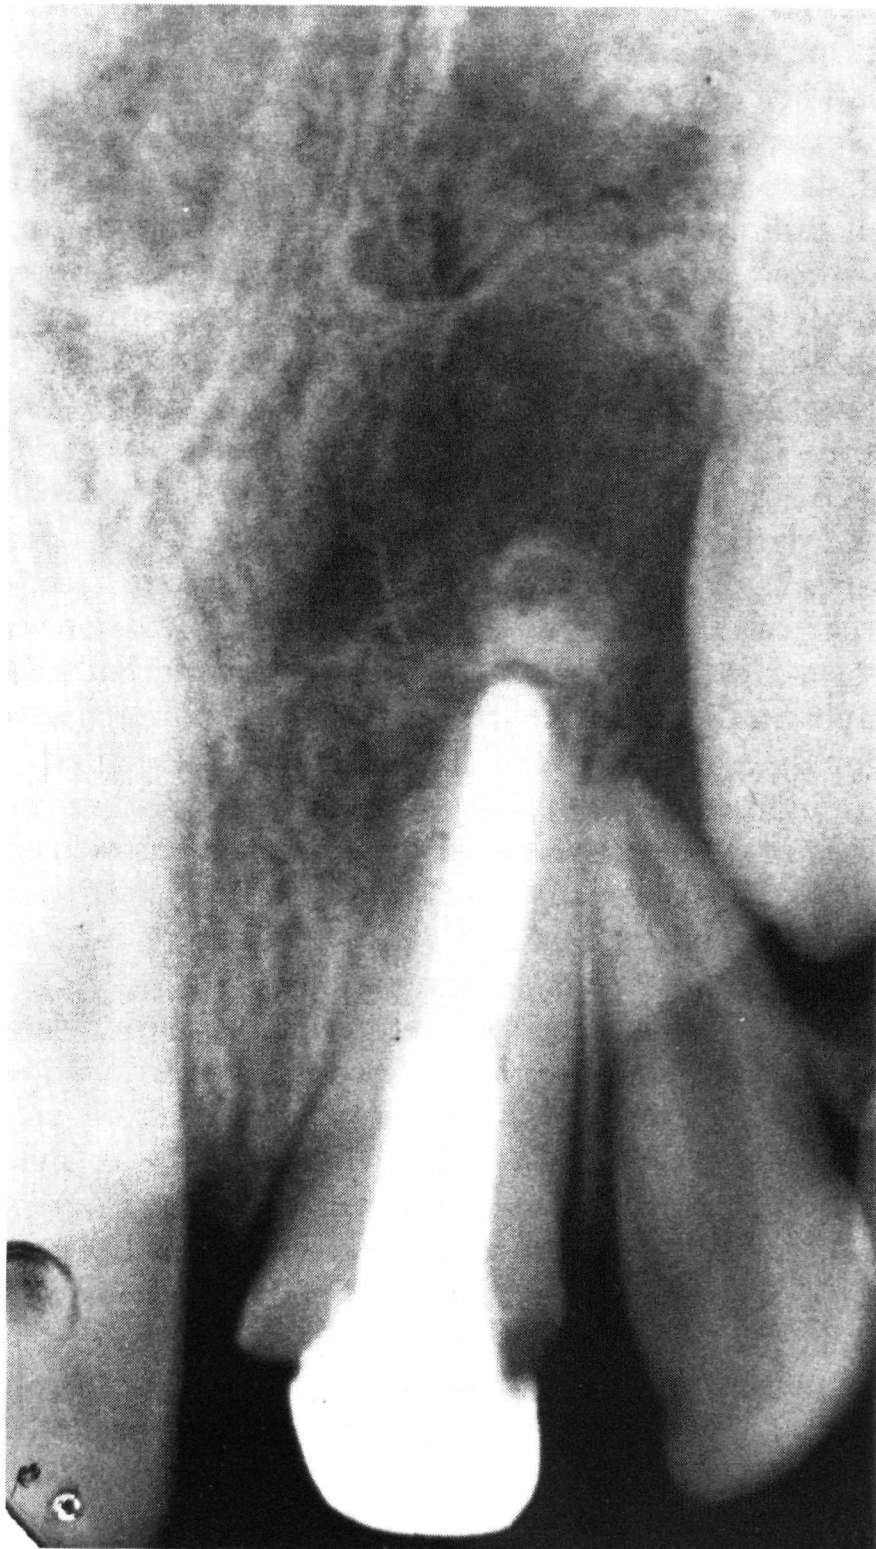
Same case as in Fig. 1 showing 21-month recall radiograph. Significant apical bone regeneration has occurred.
